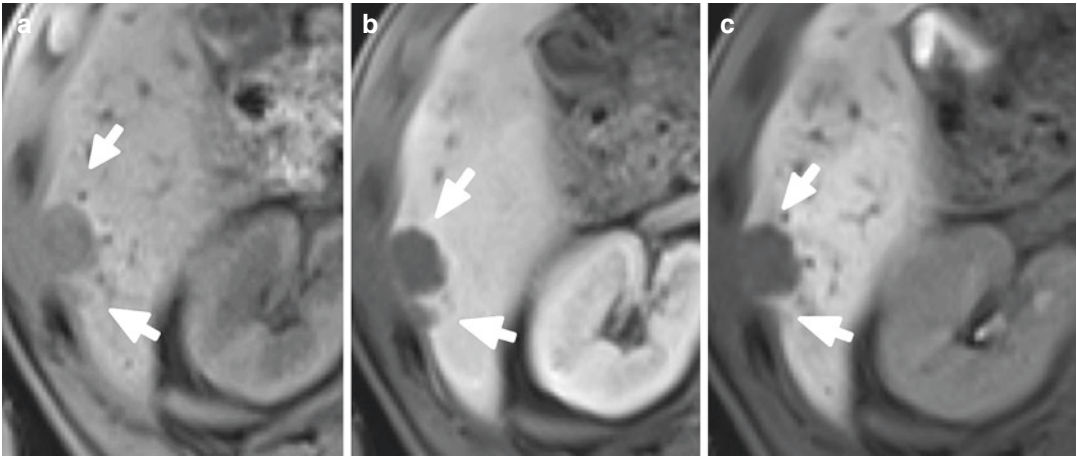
Two adjacent CLMs in liver segment VI (arrows). (a) Hypointense signal in unenhanced T1w MRI. No contrast uptake 60 s (b) and 10 min (c) after
